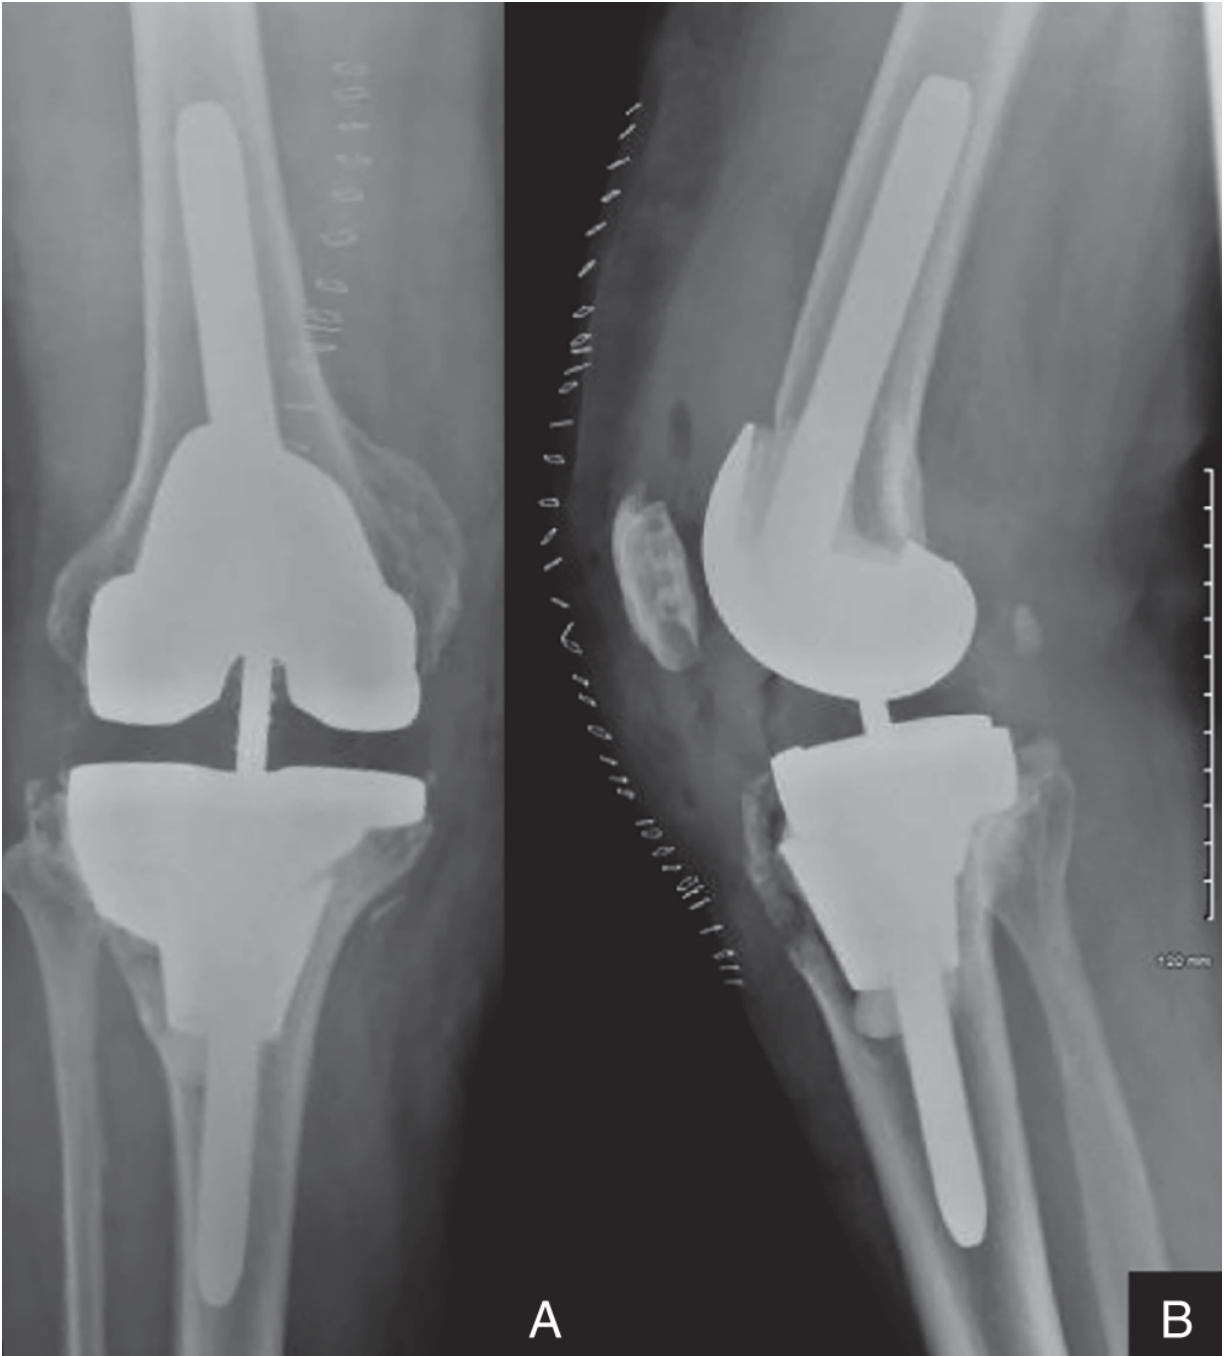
Postoperative radiographs showing a revision TKA utilizing a porous cone and hybrid cemented stem technique on both the tibial and femoral sides.
